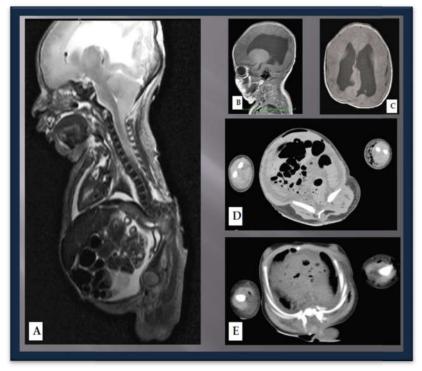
MRI & CT scan images; A - T2W MR sagittal section of fetus showing dilated lateral ventricle, compressed 4<sup>th</sup> ventricle, herniation of cerebellar tonsil, angular kyphotic deformity T6-L5 vertebral levels, thoraco lumbosacral spina bifida - meningomyelocele, tethered cord at T6 onwards. No pre-sacral mass detected. B & C - T1W MR sagittal and transverse sections of skull showing bilateral colpocephaly, underdeveloped/distorted corpus callosum. D - shows the sacral agenesis on left side - hemisacrum. Sacral anomaly Type 4 of Cama *et al* (1996). E – shows thoraco lumbosacral open spina bifida - meningomyelocele
